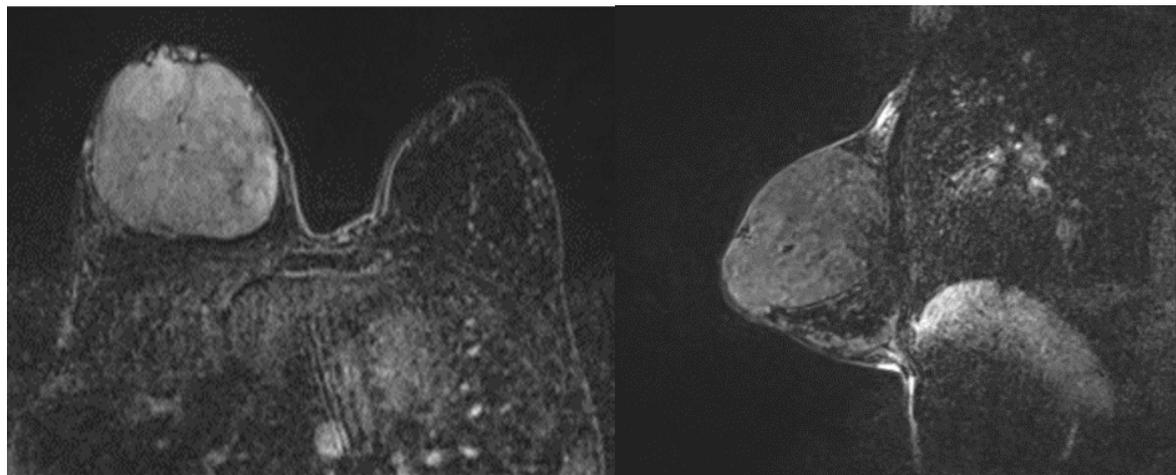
MRI postcontrast sequence axial and sagittal view suggesting inhomogeneous breast tumor compressing normal breast tissue.
